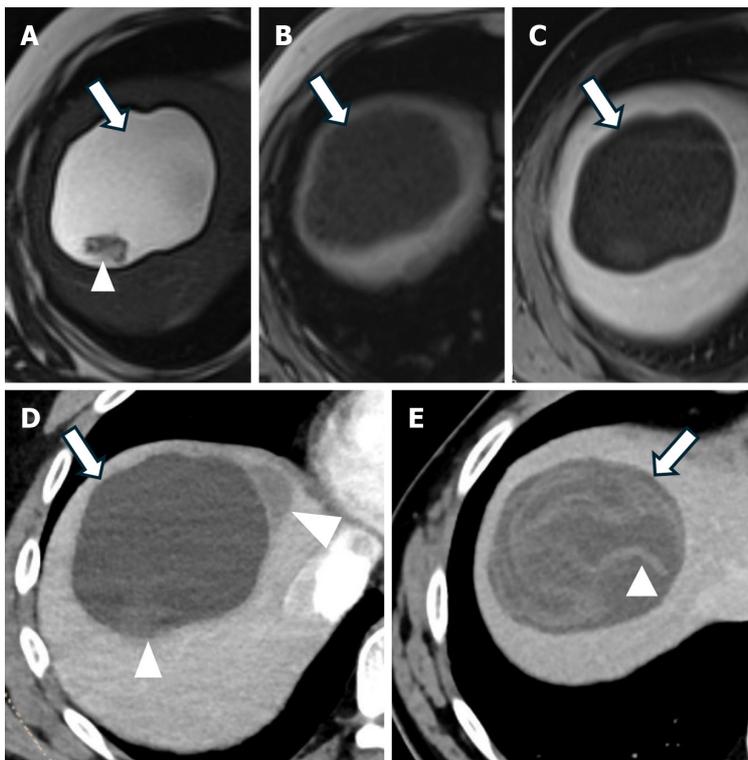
World Health Organization CE2 and CE3a type hydatid cysts. A 35-year-old man with nonspecific right upper quadrant pain. A: Axial T2 weighted magnetic resonance imaging (MRI) shows a T2 hyperintense hydatid cyst [World Health Organization (WHO) type CE2] with a solitary main cyst (arrow) and small daughter cysts (arrowhead) posteriorly; B: Axial T1 weighted MRI shows a T1 hypointense hydatid cyst with a solitary main cyst (arrow); C: Axial T1 weighted MRI with an extracellular gadolinium-based contrast agent in the portal venous phase shows a hydatid cyst that demonstrates no enhancement; D: Axial contrast-enhanced computed tomography (CT) image shows a hydatid cyst with the main cyst (arrow) and daughter cysts (arrowheads); E: Axial contrast-enhanced CT image of the same patient after one year shows a hydatid cyst (arrow) (WHO type CE3a) with detached membranes (arrowhead) floating within the main cyst.
